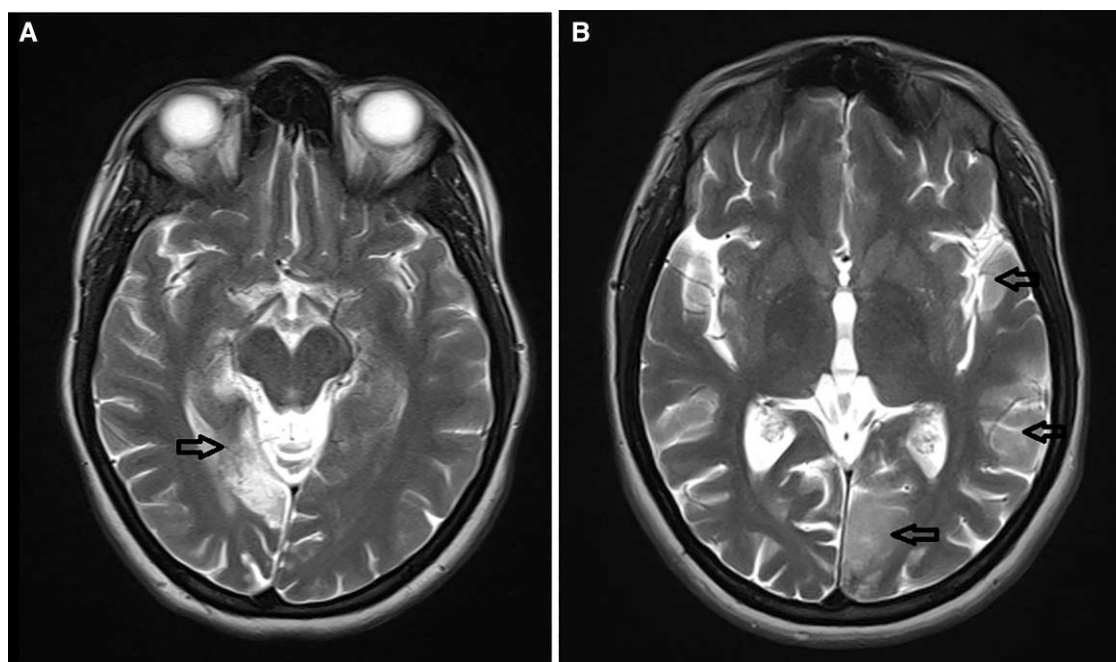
(A) MRI brain—T₂-weighted image showing hyperintense signals suggestive of acute infarct in the right posterior cerebral artery territory. (B) MRI brain—T₂-weighted image showing hyperintense signals suggestive of acute infarcts involving the left posterior cerebral artery territory, left parietal cortex and left superior frontal gyrus.
